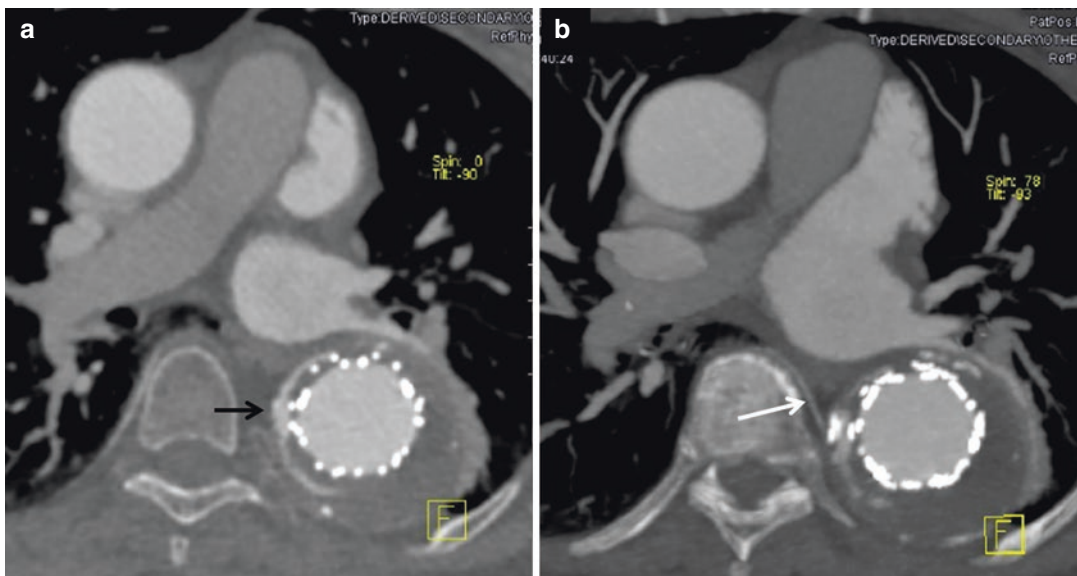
Endoleak type II. (a) Axial CT scan (*black arrow*); (b) elaborate maximum intensity projection (MIP) shows intercostal artery (*white arrow*)
